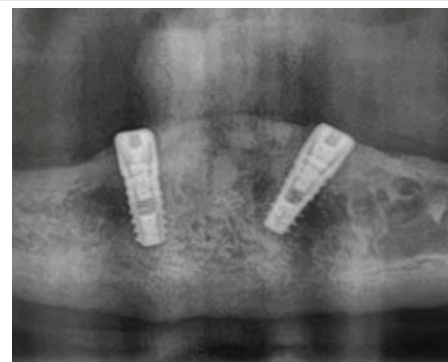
Immediate postoperative panoramic radiograph demonstrating successful placement of two dental implants in the interforaminal region of the severely resorbed edentulous mandible. The implants exhibited appropriate angulation and positioning within the available alveolar bone, providing the foundation for a mandibular implant-retained overdenture.
